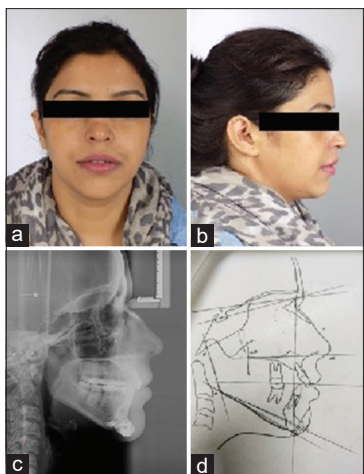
(a) Preoperative Front Profile. (b) Preoperative lateral profile. (c) Preoperative radiographs. (d) Preoperative tracing
